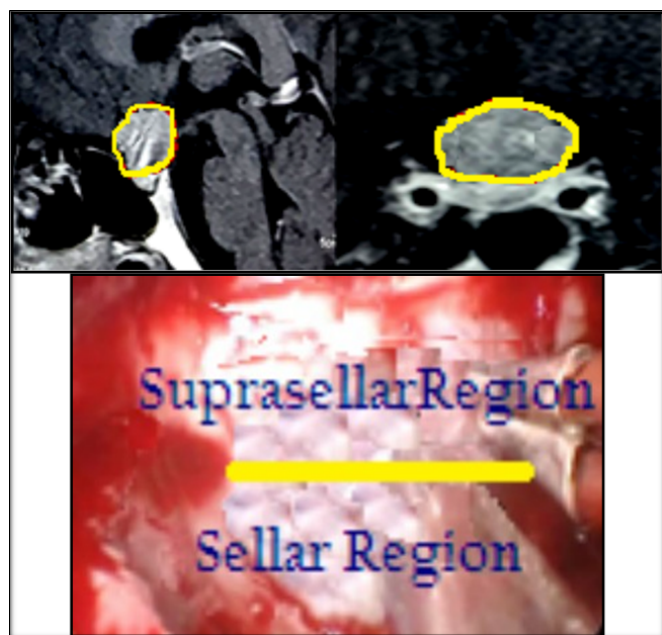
The solid mass is in the saddle and suprasellar area, showing uneven enhancement. (Coronal and sagittal view of MRI), b-After removal of the saddle floor bone, we can see the boundary between the saddle and suprasellar area.
